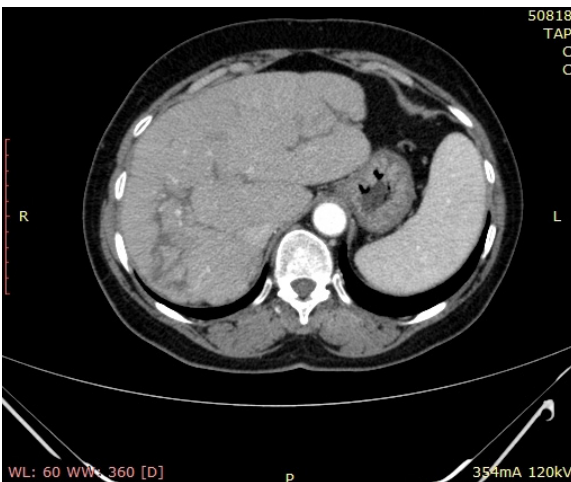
CT scan showing dysmorphic liver with hypertrophy of segments VIII, VII and IV
